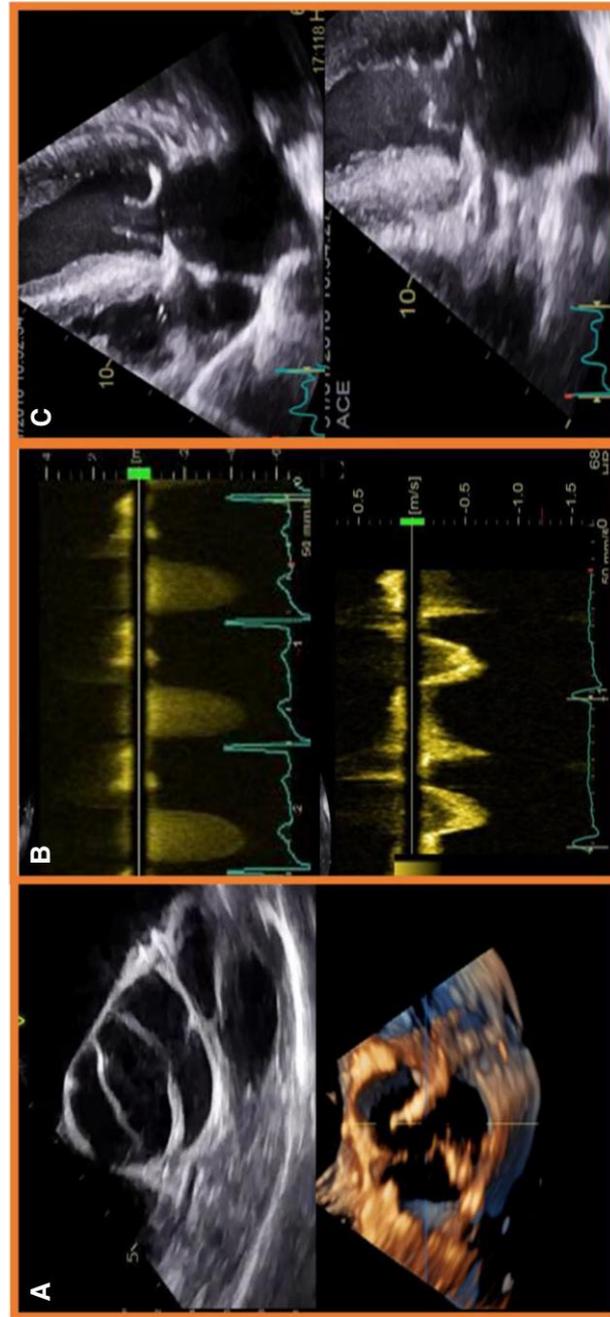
Valvular and myocardial assessments by echocardiography. Echocardiography has the ability to assess the valve morphology and haemodynamics as well as myocardial remodelling and function. (A) Bicuspid aortic valve (top) and 3D echocardiography assessment of a stenotic aortic valve (bottom). (B) Measurement of peak velocities through the valve (top) and LVOT (bottom). (C) Assessment of myocardial structure and function on cine imaging.
